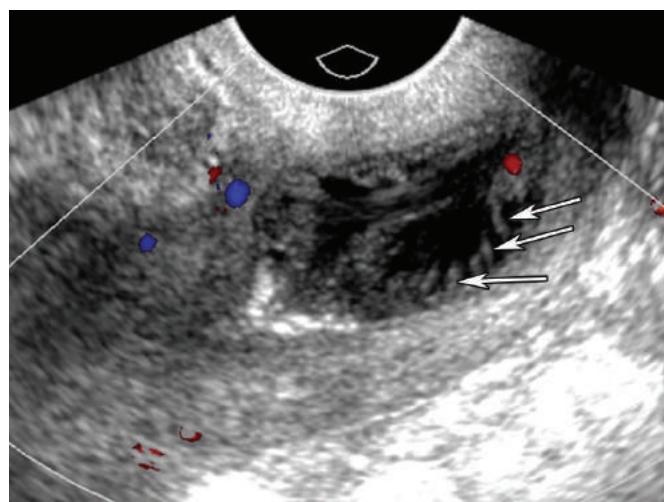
Sagittal US scan showing a complex fluid collection in the cervical canal; note the presence of plicae palmatae (arrows) as well as the absence of colour Doppler flow signal within the cervical canal.
